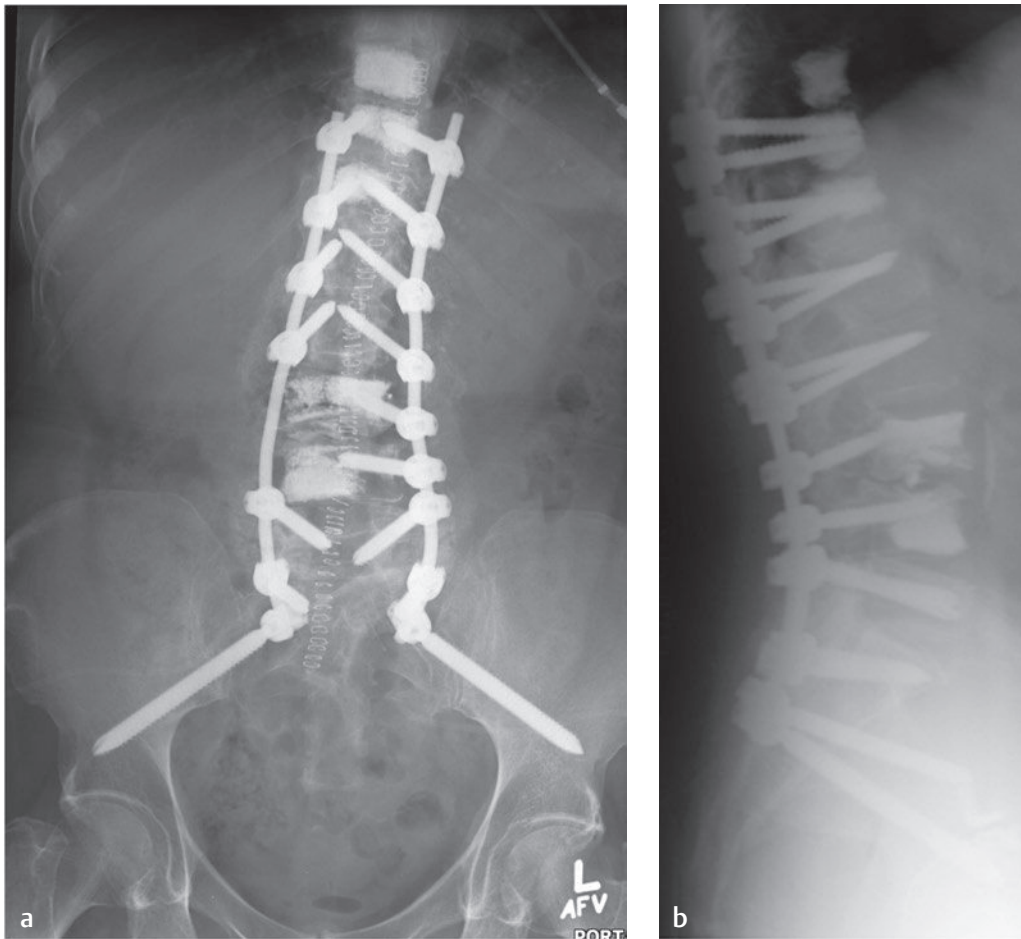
Conventional radiographs of a patient with a history of osteoporosis who underwent revision surgery for thoracolumbar scoliosis and stenosis. (a) AP and (b) lateral images show an instrumented fusion from T11 to the pelvis with screw augmentation with polymethylmethacrylate cement at the T11 and T12 levels and prophylactic vertebroplasty at the T10 level. The vertebroplasties at the L3 and L4 levels had been performed previously.
